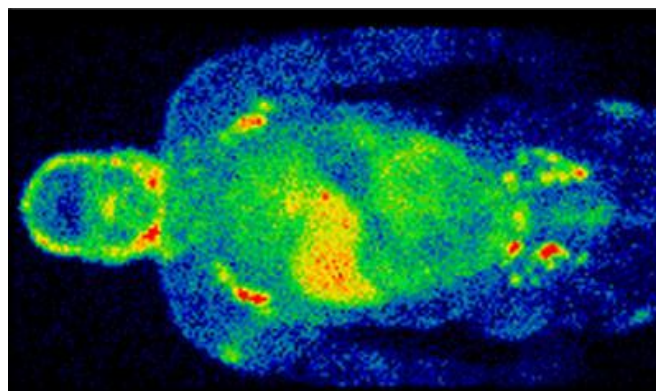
Single Photon Emission Computed Tomography (SPECT) total body scan.
